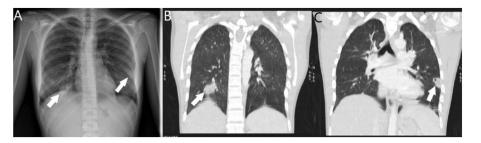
Chest X-ray (A): pulmonary condensations with a tendency to cavitation. Coronal reconstruction of the CT (B and C) with lung window that facilitates better definition of the lesions, with cavitation in the left lower lobe.
